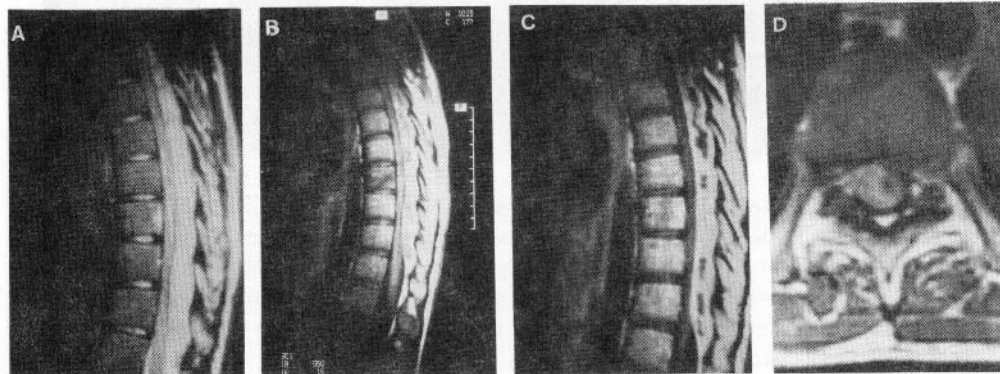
Arachnoiditis with subdural collection. T2-weighted sagittal image (a) of the thoracic spine shows diffusely hyperintense cord with posterior margin visualized. On T1-weighted image (b) the center of the cord appears hypointense as compared with the periphery and the cord above. Posterior to the cord, there is a thick linear hypointense area. Postcontrast image (c) shows the hypointense area (arrows) to lie between the enhancing leptomeninges and the posterior dura consistent with subdural collection.
